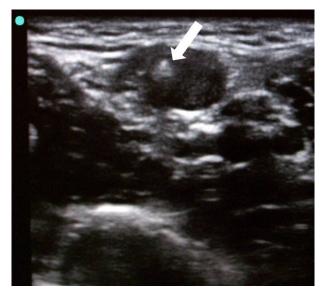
Sonographic image of an out-of-plane technique with visualization of the needle and cannula (arrow) entering the artery.
